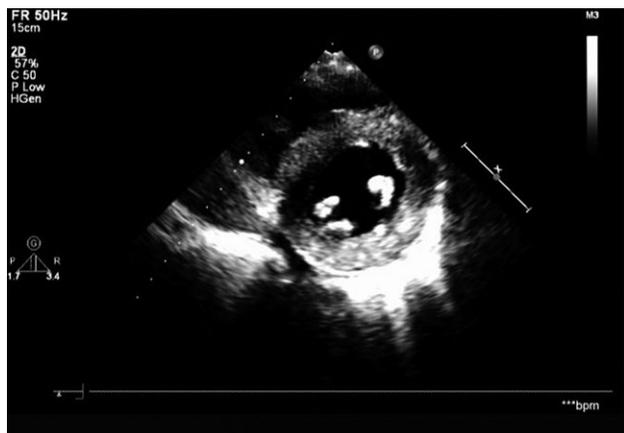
Echocardiography showing cardiac muscle and left ventricular papillary muscle echo enhancement.
